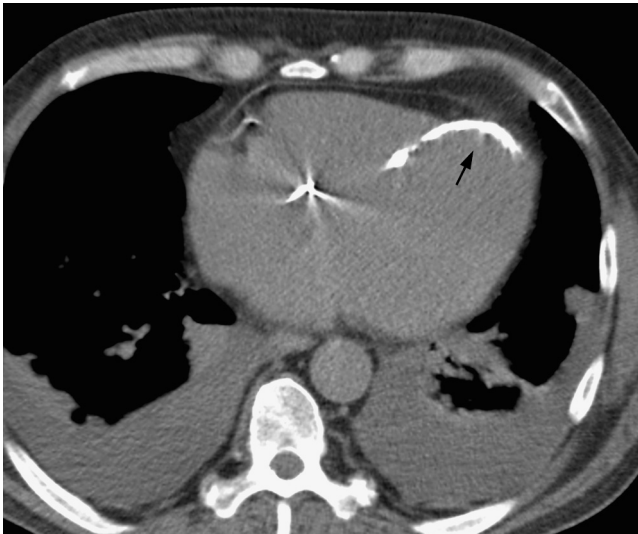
A 52-year-old man with ischemic cardiomyopathy undergoing chest computed tomography (CT) evaluation. An axial CT image, showing a rim of calcification in the nonviable left ventricular myocardium (arrow) from a previous extensive left anterior descending territory myocardial infarction with the presence of bilateral pleural effusions. A single lead pacing wire is seen crossing the tricuspid valve.
